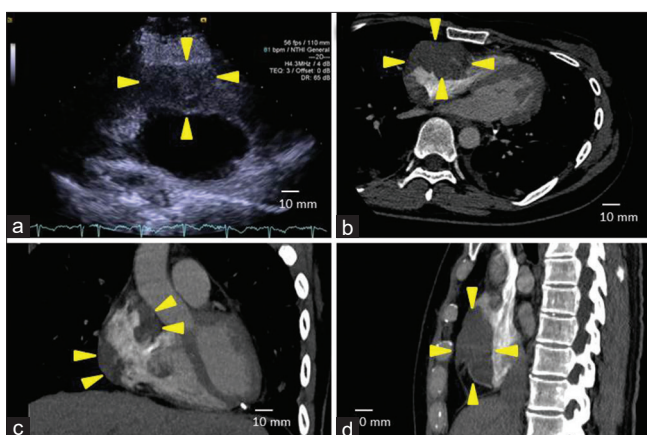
Images of intracardiac mass at the time of initial consultation. (a) Transthoracic echocardiography shows a hypodense mass attached to the anterior atrial free wall (arrowhead), (b) contrast-enhanced computed tomography (axial view). Arrowhead: intracardiac mass in the right atrium, (c) contrast-enhanced computed tomography (coronal view). Arrowhead: intracardiac mass in the right atrium, (d) contrast-enhanced computed tomography (sagittal view). Arrowhead: intracardiac mass in the right atrium
